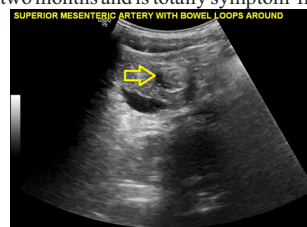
Ultrasound image showing Whirlpool Sign (Yellow arrow)
